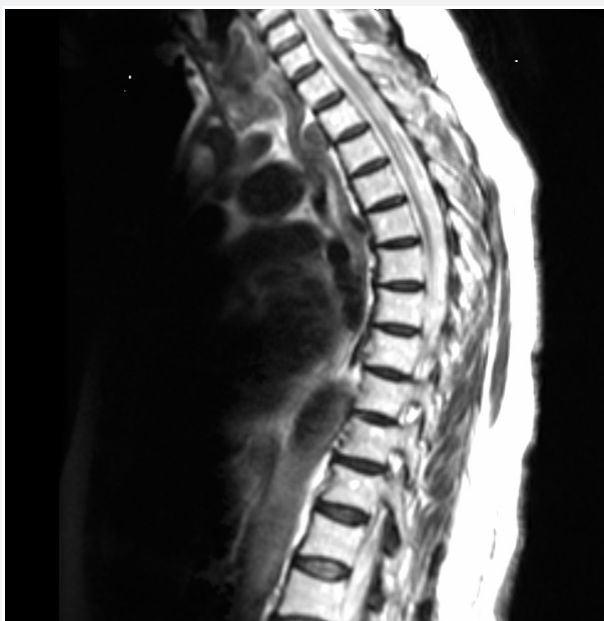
MRI of the thoracic spine indicated prominent Cerebro Spinal Fluid (CSF) density from T1 to T4 with no evidence of cord mass or tumor and CT of the right leg showed mild edema.
